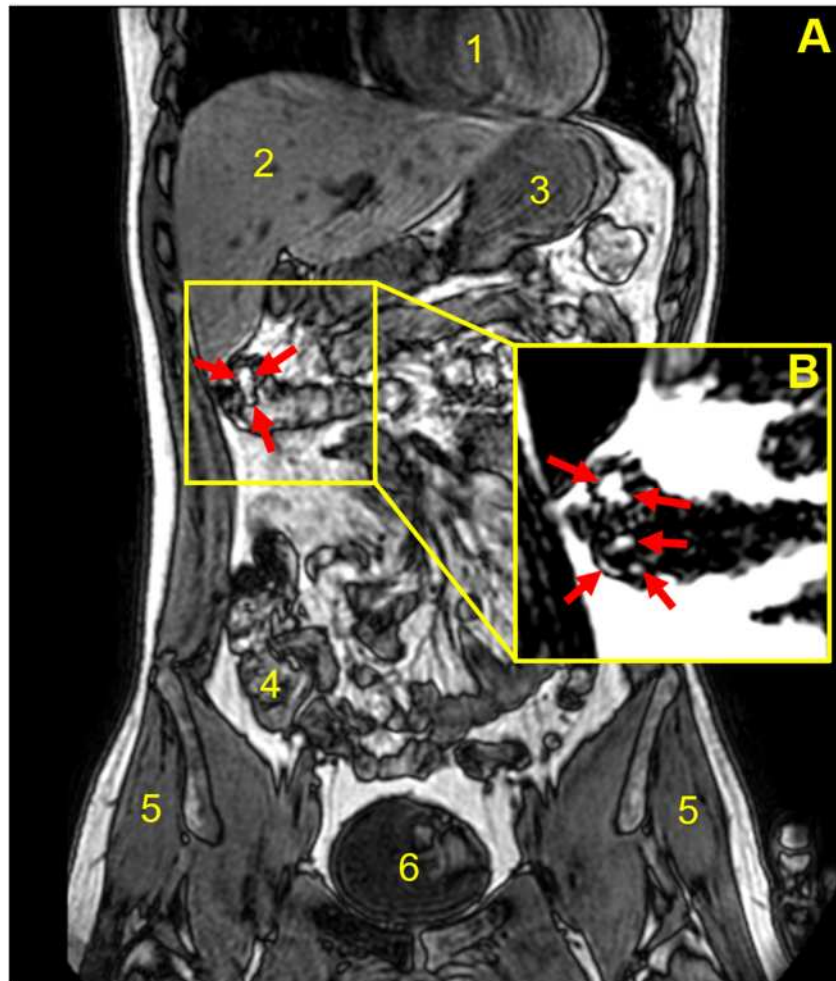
Coronal, fat and water out of phase MRI image of the abdomen of participant number 3, acquired 180 min after consumption of the coated capsule with 240 mL of water. Anatomical landmarks are indicated in by numbered labels: heart (1), liver (2), stomach fundus (3), transverse colon (4), gluteus medius muscle (5) and bladder (6). (A) The filled capsule appears bright and is located in the ascending colon/hepatic flexure of the large intestine. The capsule here appeared deformed and unevenly filled. The inset (B) is from the corresponding fat only MRI image, capturing oil leaks out of the capsule into the colon indicated by the red arrows.
